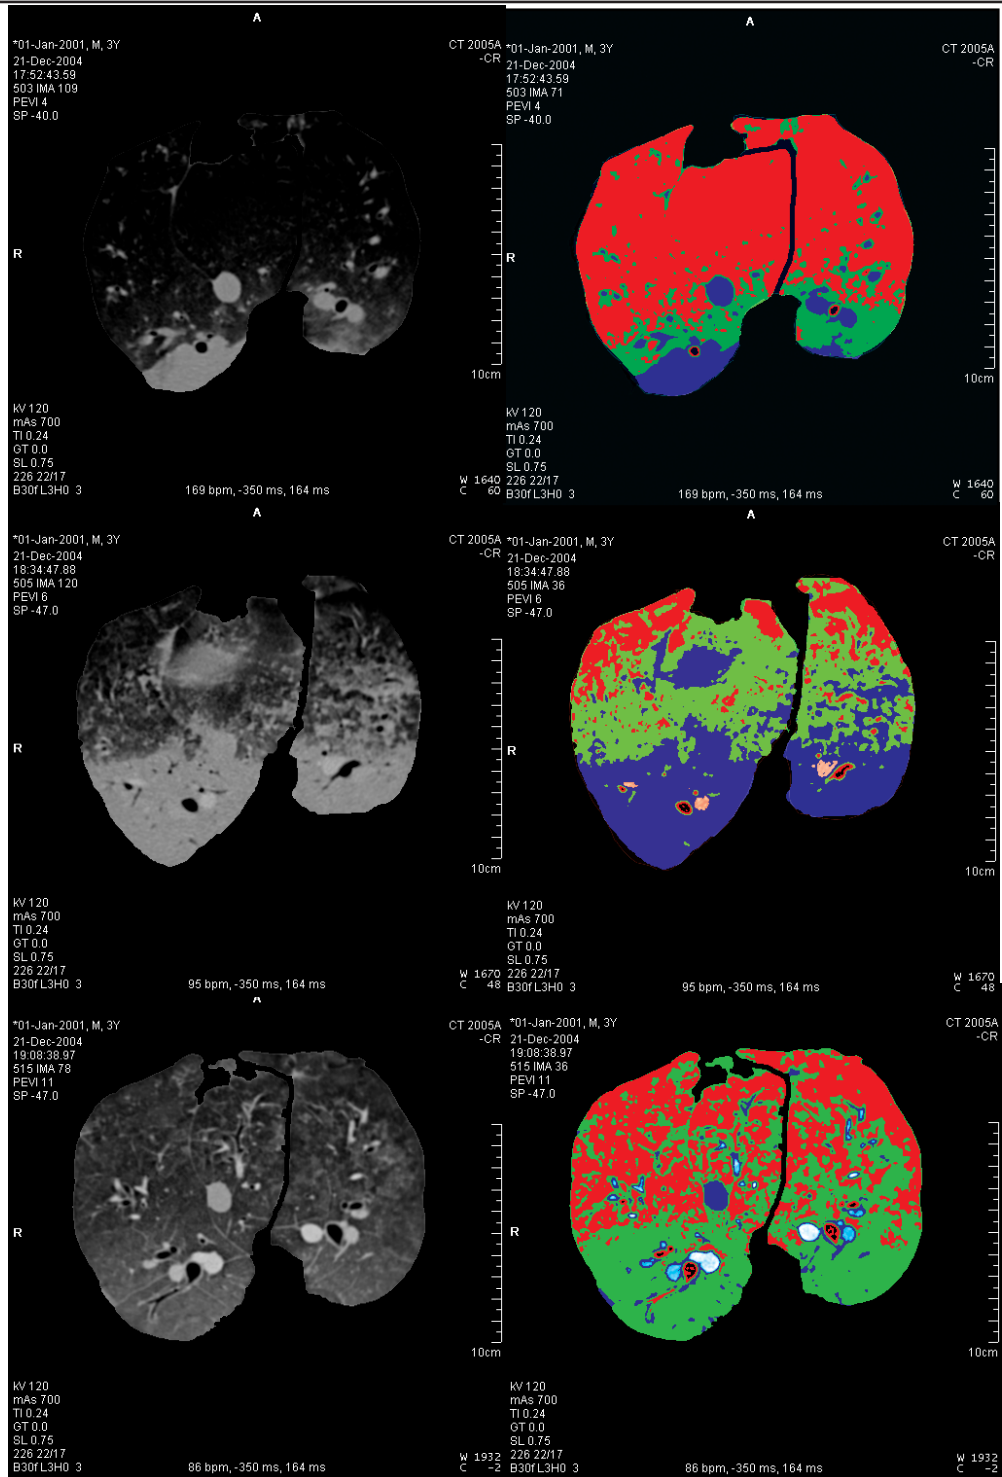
CT-scan examples of basal lung areas during expiration. Upper 2 scans are during baseline, before lung lavage. Middle 2 scans are CMV ventilation after lung lavage, lower 2 scans are during OLC ventilation after lung lavage. Good aerated lung areas (HU -1000 to -600) are coded red in the right-hand scans, poorly aerated areas (HU -600 to -200) are coded green, and non-aerated lung areas (HU -200 to 200) are coded blue.
